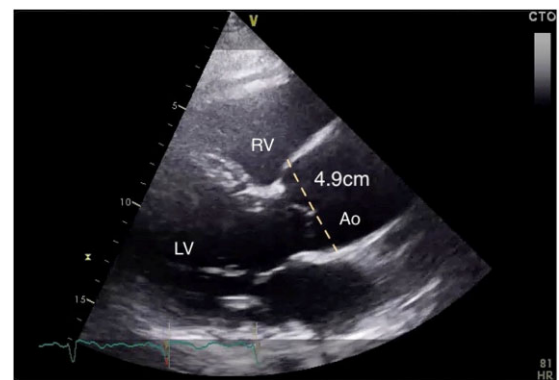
2D echocardiogram (parasternal long-axis view) showing the dilated aortic root. Ao, aortic root; LV, left ventricle; RV, right ventricle.
